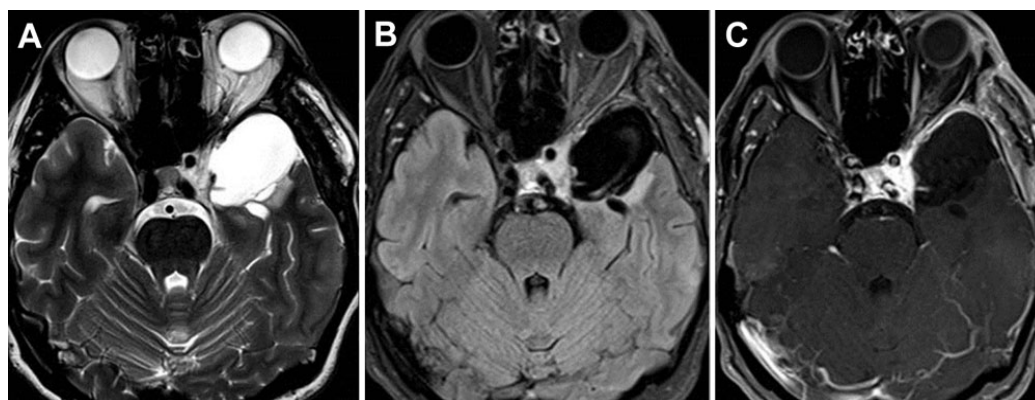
Postoperative magnetic resonance images. (A) Axial T2W sequences show fluid signal collection in the left parasellar region; (B) axial FLAIR reveals suppression of fluid signal; (C) axial post-contrast T1 shows no contrast enhancement, suggesting no residual lesion
